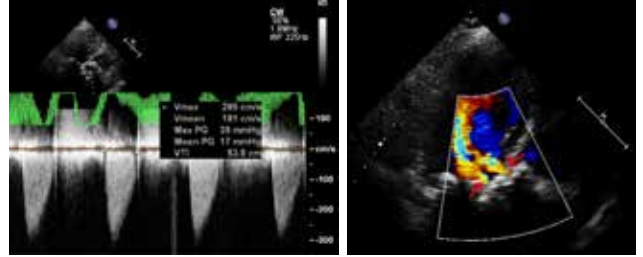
(D) Follow-up transthoracic Doppler echocardiography at 4 years follow-up with 5-chamber continuous wave Doppler analysis showing a mean gradient of 17 mmHg. (E) Mild bilateral paravalvular aortic regurgitation (arrows) at parasternal long axis view.
